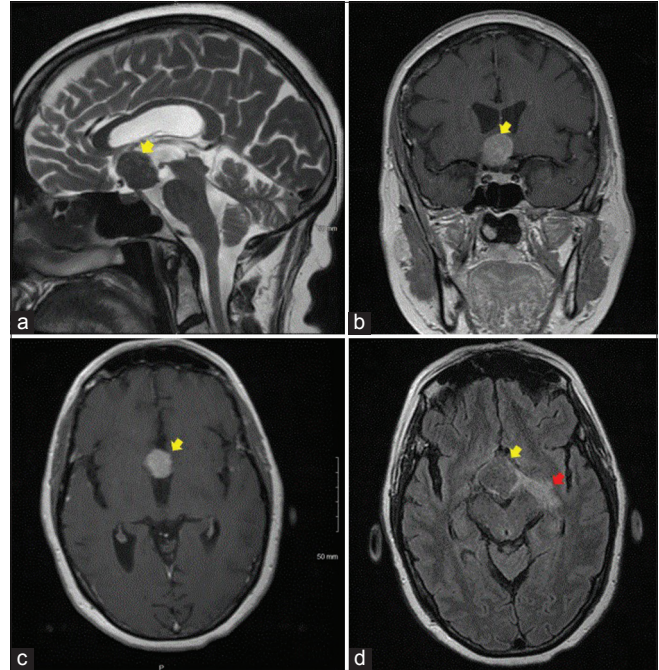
MRI findings of the granular cell tumor (yellow arrow). The lesion was hypointense on T2 image (a). It was enhanced homogeneously (b). The lesion invaded into the third ventricle (c) and caused optic tract edema (d, red arrow).
